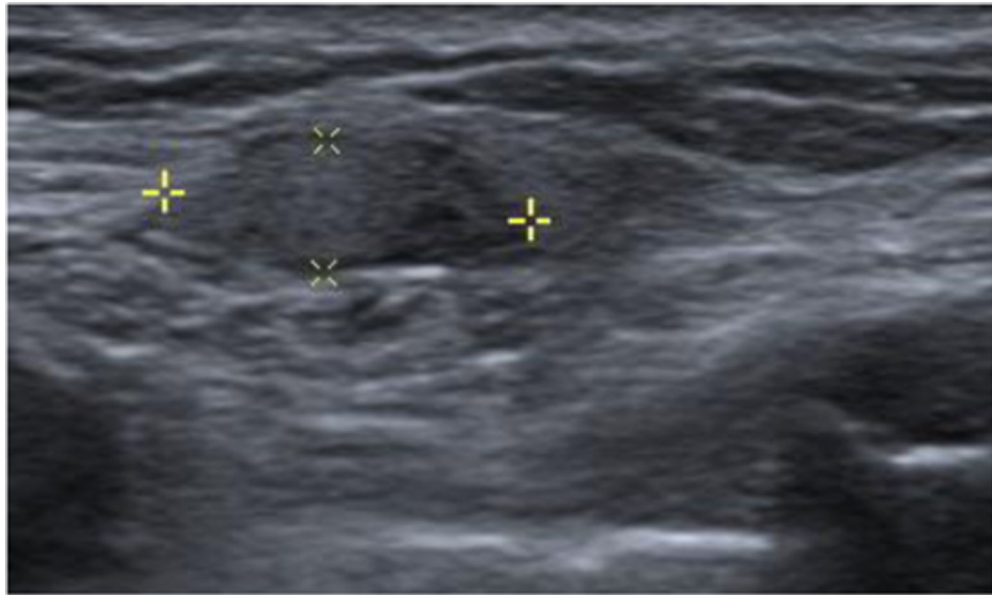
Patient status post right mastectomy with TRAM flap reconstruction and palpable mass in the medial right breast. On ultrasound (Fig. 6a) it was oval, parallel and iso to hyperechoic with no vascularity (arrow). MRI (Fig. 6b and c) show a heterogeneously enhancing mass in the medial reconstructed breast.
